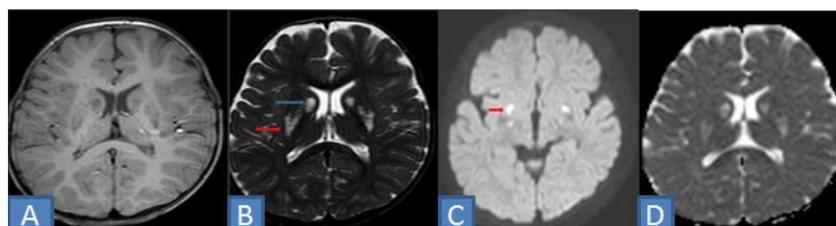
A case of Leigh’s disease showing bilateral hypointense lesions in Lentiform nuclei on T1WI (A), appearing hyperintense on T2WI (B), showing restriction on DWI (C), with low ADC values (D)
